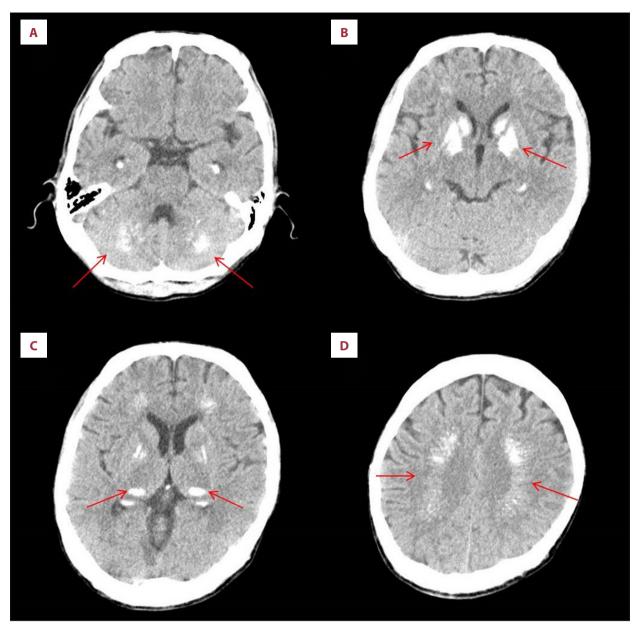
Brain computed tomography (CT) showed bilateral symmetrical calcification in cerebellar white matter, the corpus striatum, the posterior thalami, and the centrum semiovale of both cerebral hemispheres: (A) cerebellum white matter; (B) corpus striatum; (C) posterior thalami; (D) centrum semiovale of both cerebral hemispheres.
